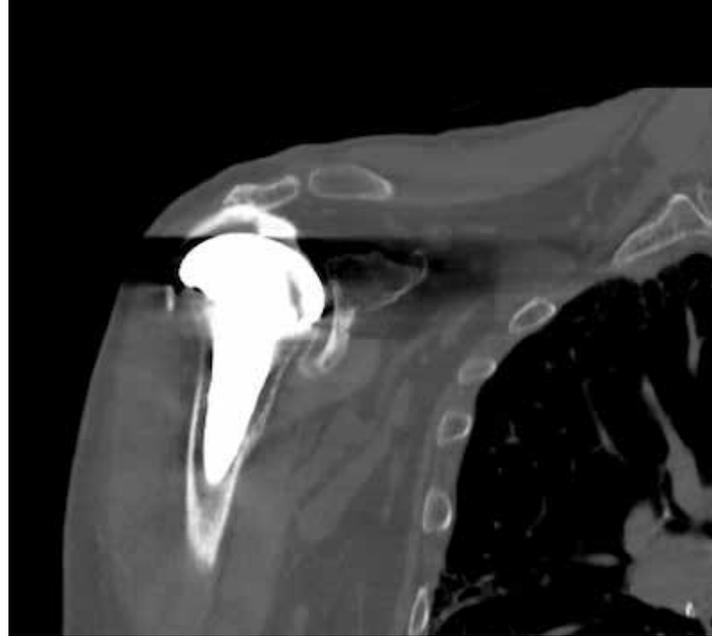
Computed tomography (CT) arthrogram of the right shoulder in a 67-year-old male demonstrating superior migration of the humeral component as well as contrast extravasation in the subacromial space indicative of a full-thickness tear of the superior rotator cuff.
